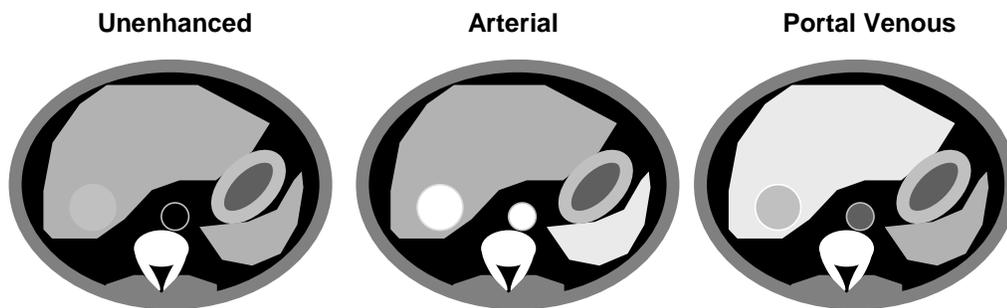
Diagnosis of hepatocellular carcinoma (HCC). The classic HCC, which may be barely perceptible on unenhanced CT or MRI, will be enhancing on the arterial phase and will demonstrate “washout” compared to the rest of the liver on the portal venous phase.
